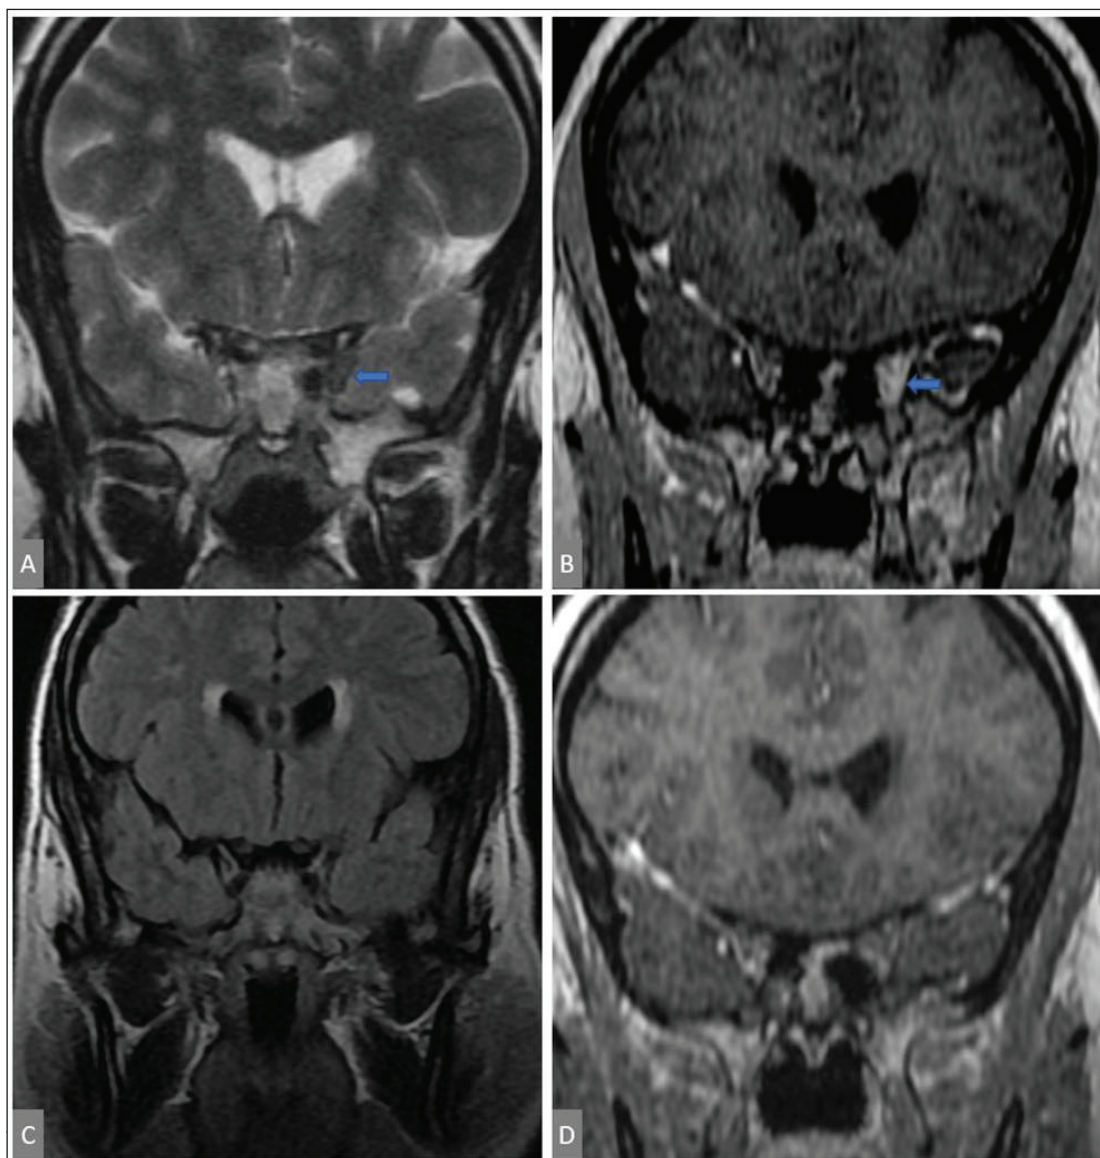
A 32-year-old woman presenting with sudden-onset left orbital pain, diplopia, and ptosis of 1-day duration. Coronal T2-weighted (a) and post-contrast T1-weighted MRI (1.5 T) (b) demonstrate an infiltrative lesion involving the left orbital apex and cavernous sinus, with intermediate T2 signal and homogeneous enhancement, without bone destruction or discrete mass formation, consistent with an inflammatory process. Diagnosis of Tolosa–Hunt syndrome was established according to International Classification of Headache Disorders 3rd edition criteria, following systematic exclusion of neoplastic, infectious, and vascular mimics. Corticosteroid response and radiological resolution on follow-up MRI at 6 months (c, d) supported the diagnosis. All images are fully anonymized and reproduced with written patient consent.
